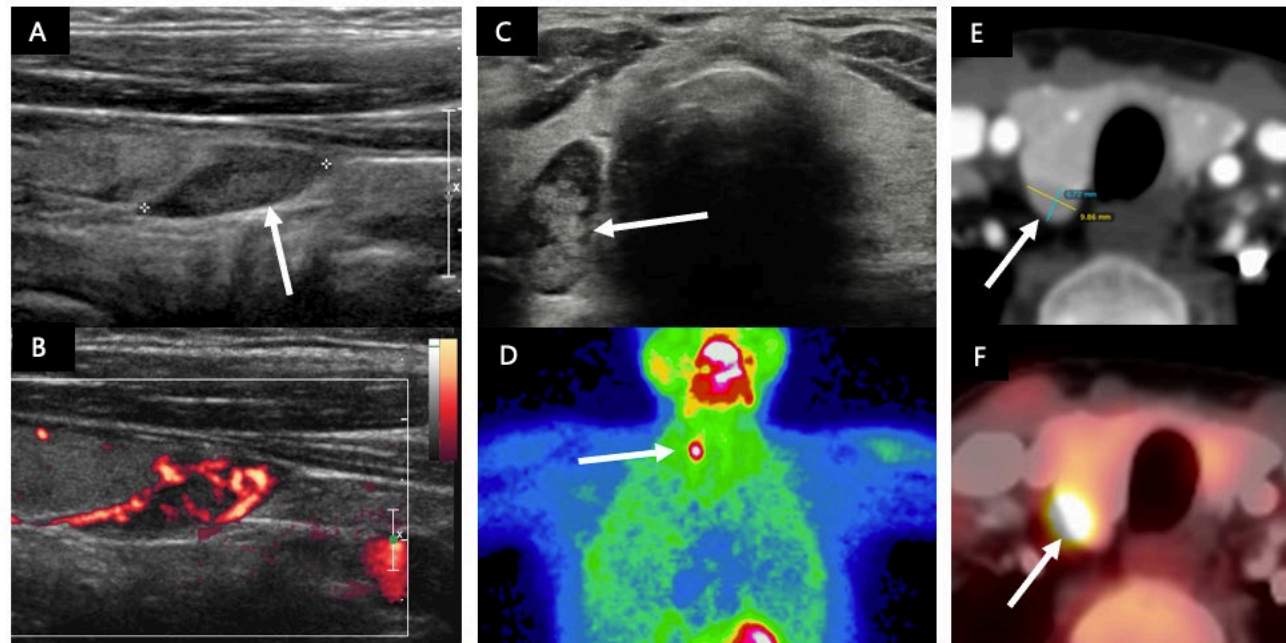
Three different patients with surgically proven parathyroid adenomas. Patient 1: Longitudinal US image (A) shows a hypoechoic nodule (arrow) below the right thyroid lobe with increased vascularisation on the power Doppler image (B). Patient 2: large parathyroid adenoma on US (C) and corresponding MIBIscintigraphy (D). Patient 3: 18F choline PET CT (E and F) shows focal uptake of an enlarged parathyroid gland (arrows) corresponding to an adenoma.
